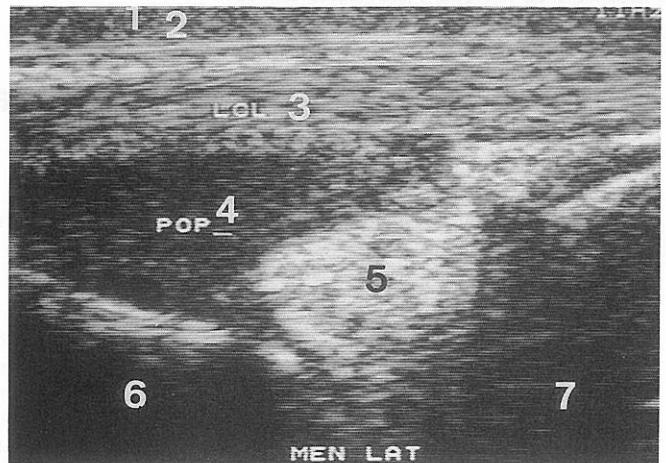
Longitudinal (frontal) ultrasound scan performed at the lateral aspect of a normal femorotibial joint of a sound 3 year-old thoroughbred filly.
